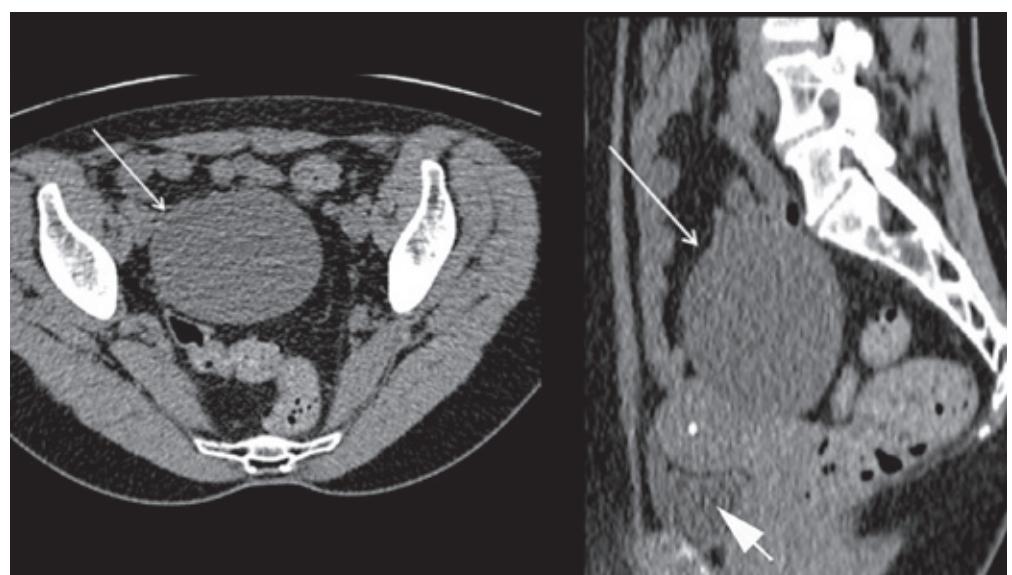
Axial and sagittal CT images from the patient in Case 2 demonstrating the ovarian cyst (thin arrow) and the collapsed urinary bladder (thick arrow).
